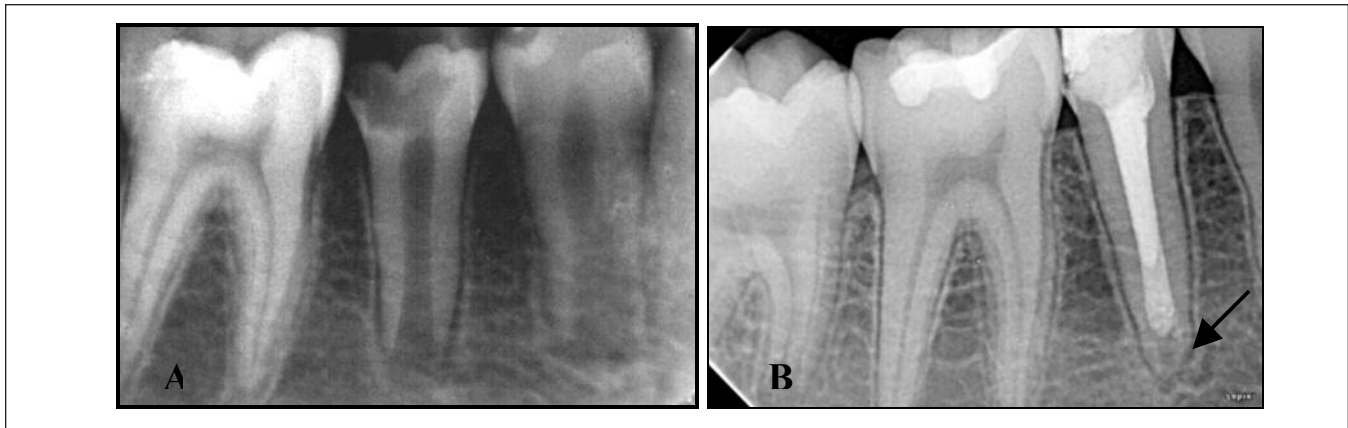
Radiographs showing the root growth A. Preoperative B. 12 month follow up
